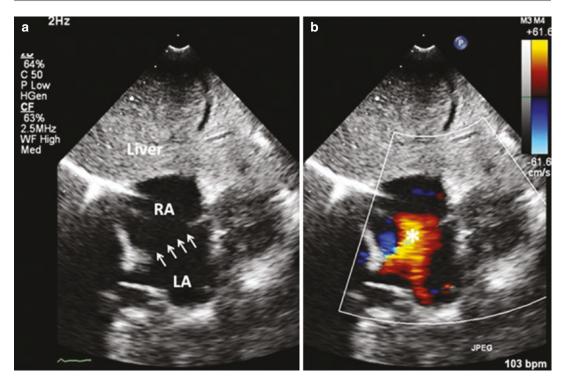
(a) 2D TTE Subcostal 4 chamber view showing a large secundum ASD (arrows). (b) Color Doppler image shows a broad flow jet directed towards the right atrium (L->R shunt)(asterisk)
